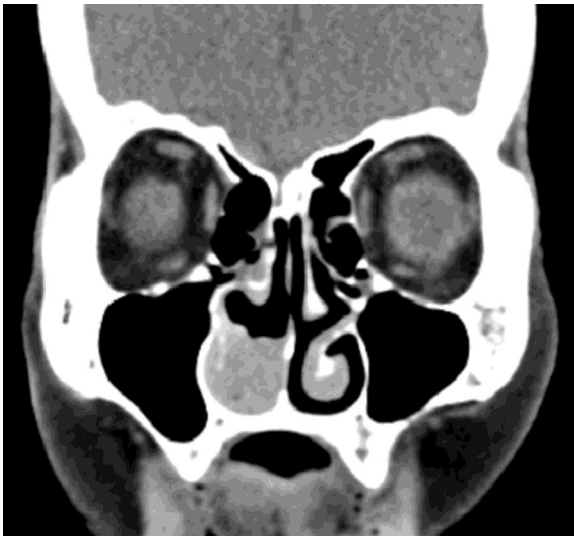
CT coronal section of the patient's face showing an enhancing soft tissue mass in the right nasal cavity.
